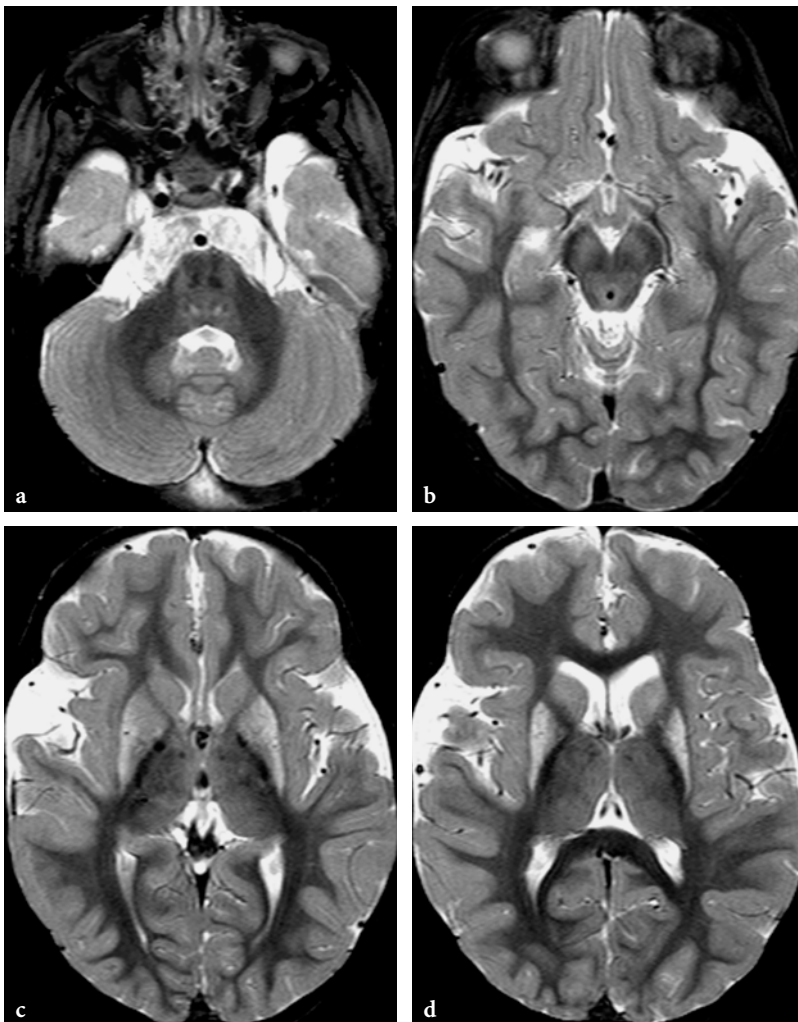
MR imaging findings in a 3-year-old female patient with glutaric aciduria type 1, who had an episode of acute encephalopathy and subsequent extrapyramidal movement disorder at the age of 7 months. Axial modular inversion recovery images of brain. a Subtle signal changes are seen within dentate nuclei, pons, and especially within central tegmental tracts. b At the level of mesencephalon the “giant panda face” lesion pattern is shown. c Subtle signal changes are suggested within the thalami. The basal ganglia are clearly abnormal; signal changes within the globi pallidi and the heads of the caudate nuclei are moderate, while they are more prominent at the level of putamina. d Incomplete bilateral opercularization and atrophy of the posterior parts of the putamina
